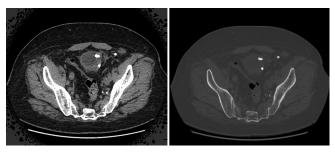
Computed tomography of the abdomen demonstrates three small calcified lesions.
